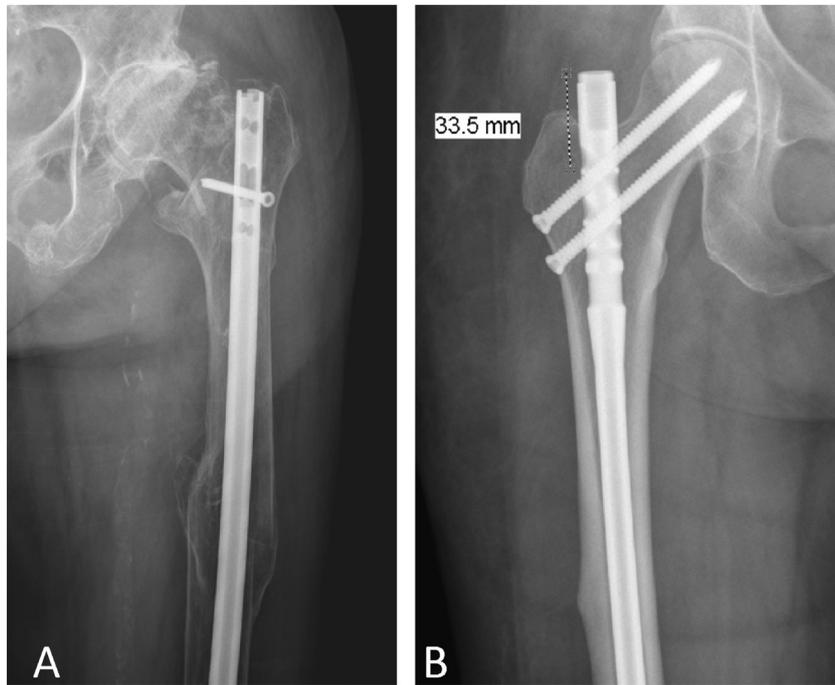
A, Anteroposterior hip radiographic of a 98-year-old female who sustained a basicervical femoral neck fracture around an intramedullary nail previously placed for a femoral shaft fracture. B, Anteroposterior hip radiograph of a patient demonstrating a notably proud piriformis start reconstruction implant after initial treatment. Note how prominent the nail is above the greater trochanter and is nearly 3.5 cm outside of the piriformis fossa.
